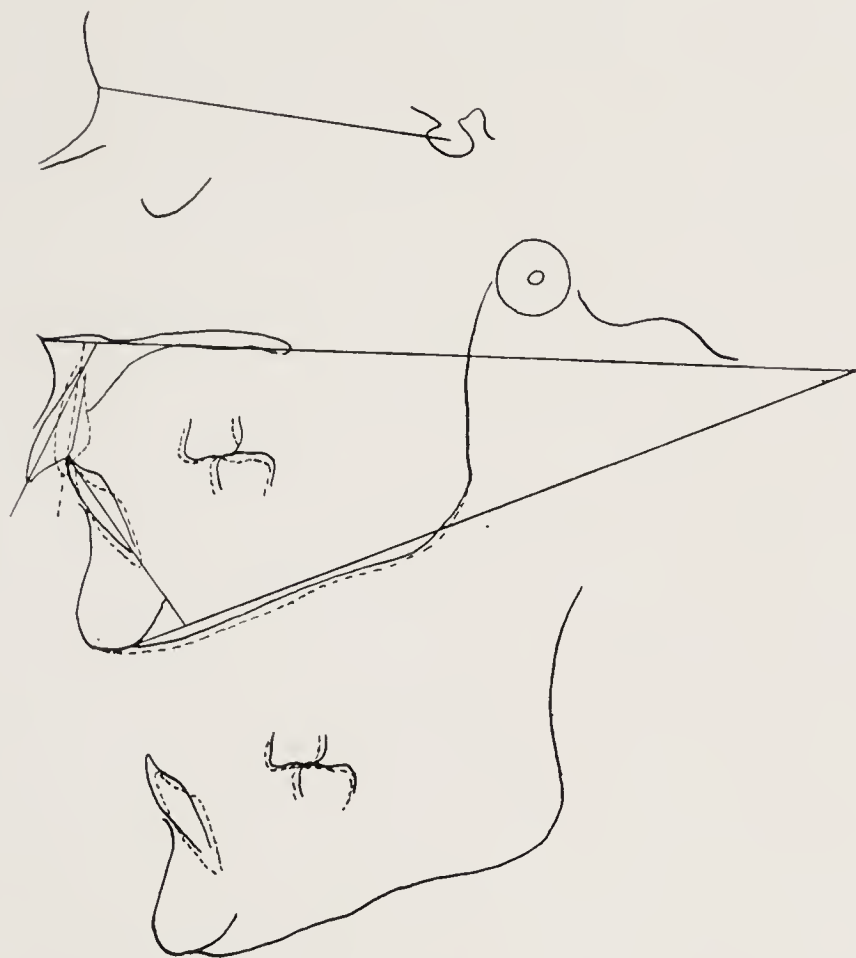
Case 3. Tracings of lateral skull radiographs, superimposed on S-N plane, and, the lower, tracings of the mandibles superimposed, showing depression of lower incisors by means of multi-banded appliances.
